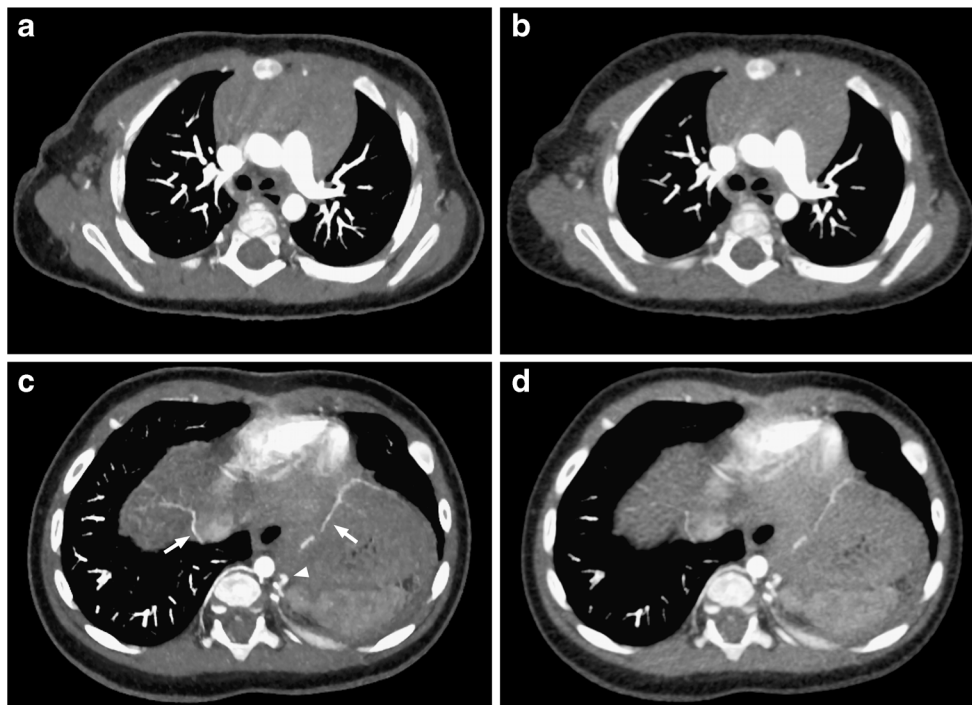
A 6-month-old girl referred to CT for further work-up of a prenatal chest mass. Images are reconstructed with Veo™ (a and c) and ASIR™ (b and d) and are representative of the datasets used to make subjective assessments of the depiction of vascular structures, image noise and resolution of small anatomical structures. In addition to the pulmonary vessels, the small vessels in the upper abdomen and lower chest including the vessels feeding the chest mass/sequestration
